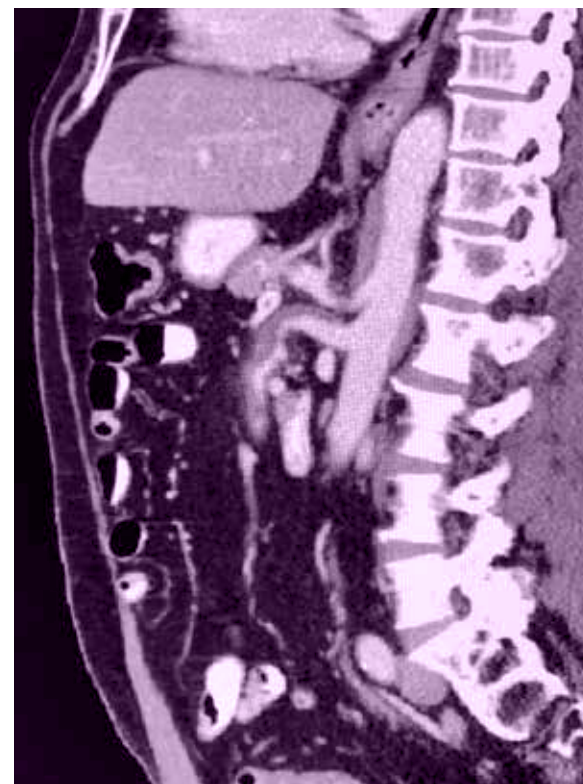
CT abdomen – sagittal view demonstrating dissection of the superior mesenteric artery.
